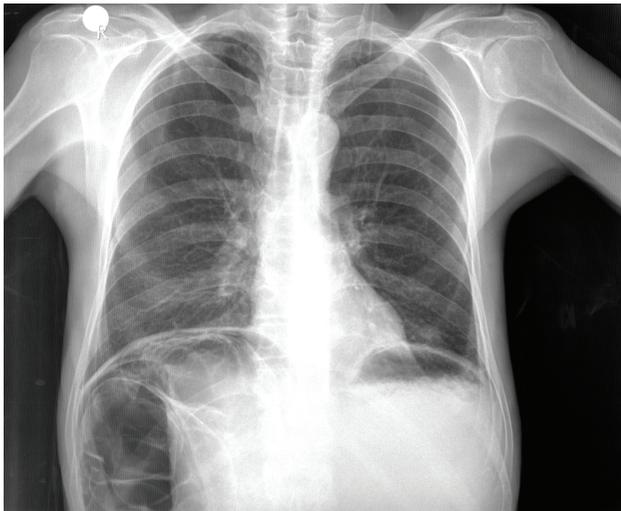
The elevation of the right hemidiaphragm and air under the diaphragm draw attention to the anterior-posterior chest X-ray.
